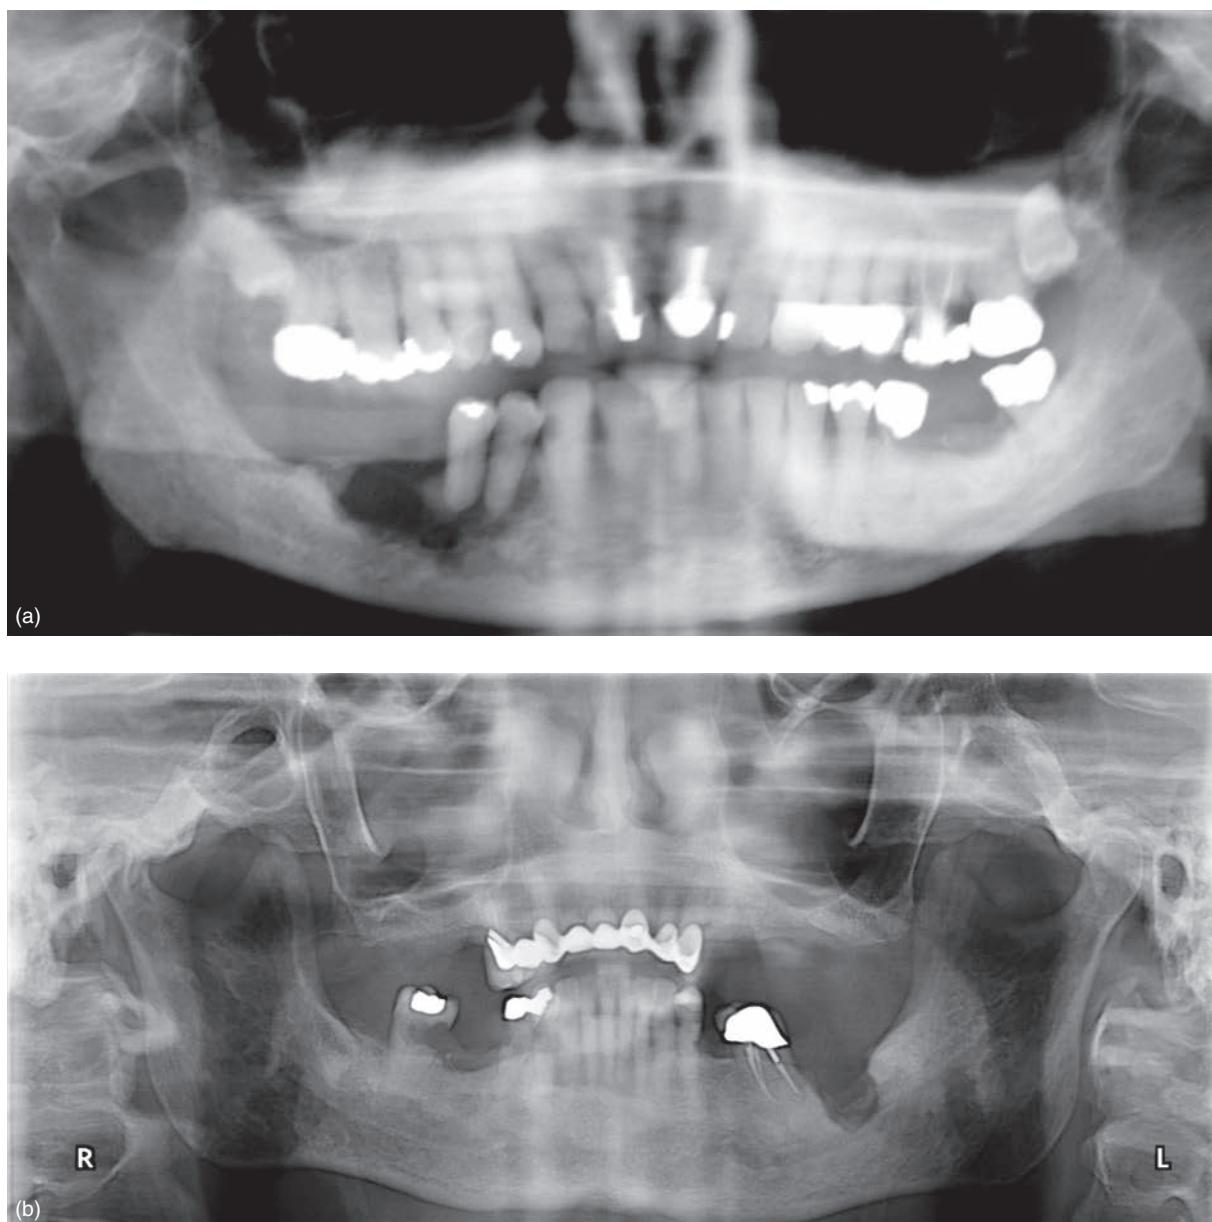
Panoramic radiographs of patients suffering from MRONJ exhibit the extent of the disease. The exposed area can extend beyond the alveolar bone and render the jaws fragile and prone to pathologic fractures. (Courtesy of Dr Jose F. Lazaro.)
